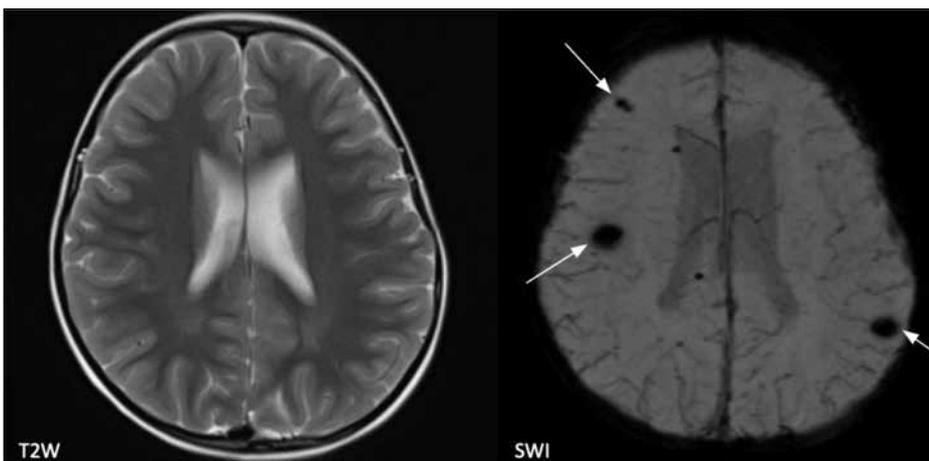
Selected axial images at the same level from T2-weighted and susceptibility-weighted imaging sequences of the magnetic resonance imaging brain showing multiple blooming artefacts (thin white arrows) at bilateral cerebral hemispheres which are only visualised on susceptibility-weighted images but not on T2-weighted images.
